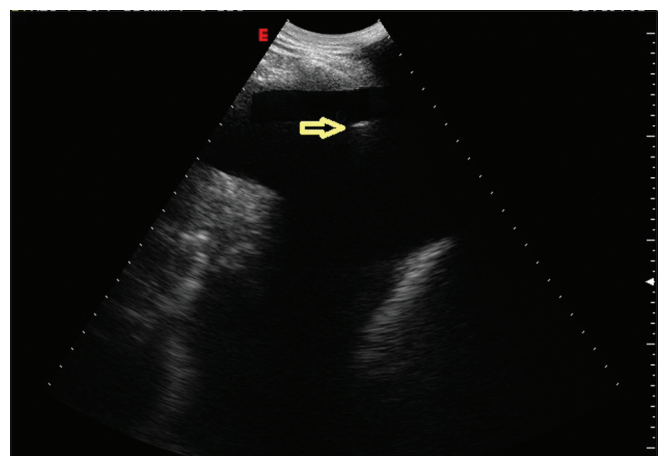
During transthoracic ultrasound-guided thoracentesis, the physician can check the needle position throughout the procedure (yellow arrow)
